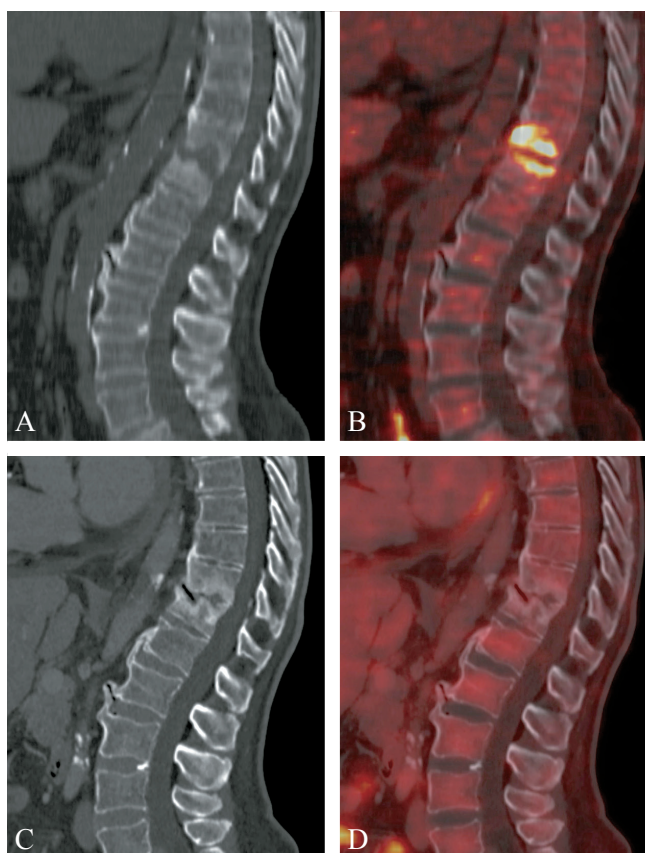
Pre- and post-treatment [^{18}F]FDG PET/CT images of a 45-year-old man with fever and back pain. Initial [^{18}F]FDG PET/CT revealed increased ^{18}F -FDG uptake at the T11-T12 level (A: CT; B: Fused PET/CT), with spondylodiscitis confirmed by spinal biopsy identifying *S. Aureus*. After three months of antibiotic therapy, follow-up PET/CT showed no ^{18}F -FDG uptake (C: CT; D: Fused PET/CT), consistent with reactive post-treatment changes following successful management of spondylodiscitis.
